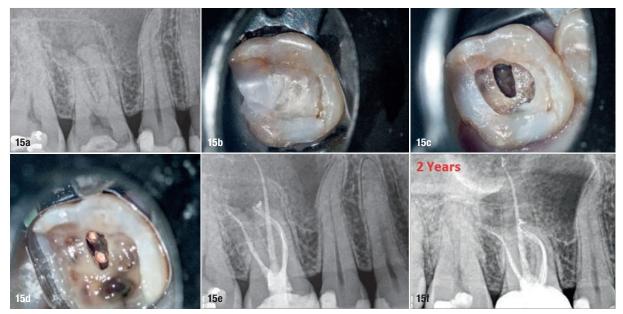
Stepped access in a maxillary molar with direct restorative material (a & b). A larger outline through the restorative material was cut (c). The mesiobuccal pulp horn was accessed first (d). The access cavity was enlarged enough to gain straight-line access to the remaining canals (e). Radiograph of the tooth, which was immediately restored at the time of obturation (f). (Case treated by Dr Bobby Nadeau)
